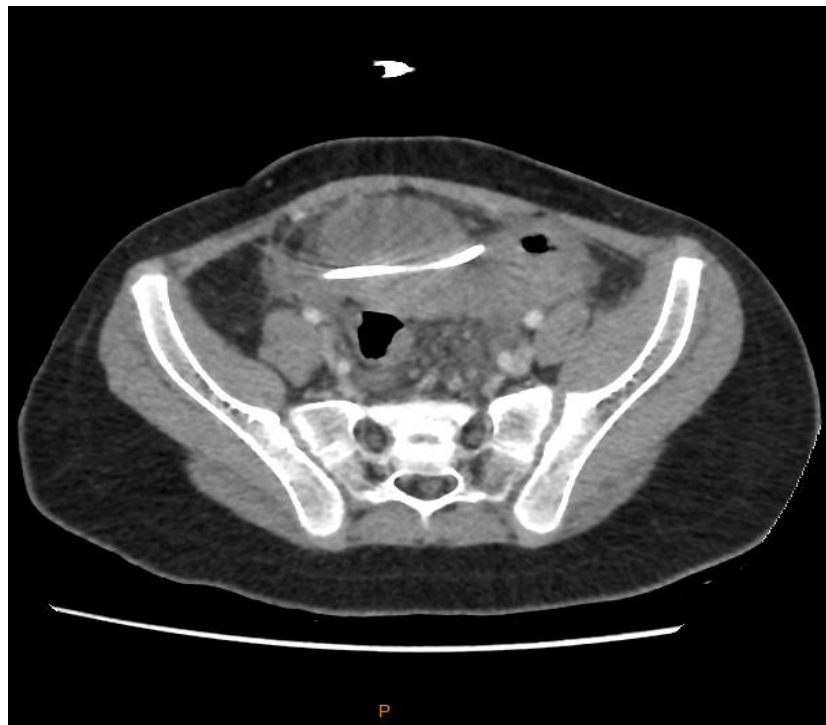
Abdominal CT scan after excision the pseudocyst and reinsertion the catheter into the left superior quadrant
